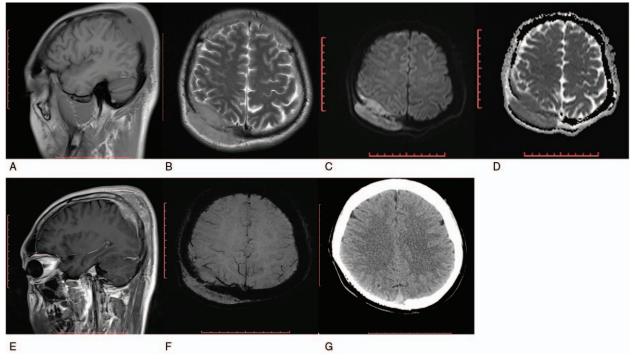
(A–D) A non-enhanced MRI scan revealing a solid mass on the right parietal occipital bone area with osteolytic erosion and intracranial and extracranial involvement. The mass was homogenous isointense on T_1 WI (A) and T_2 WI (B); and slight hyperintense on DWI (C) and hypointense on ADC map (D). (E) The mass was enhanced heterogeneously and a dural tail was seen. The neighboring brain tissue was compressed. (F) SWI showed no bleeding signals or vascular malformations in the mass. (G) There was no sign of recurrence in the CT image 12 months after surgical treatment.
